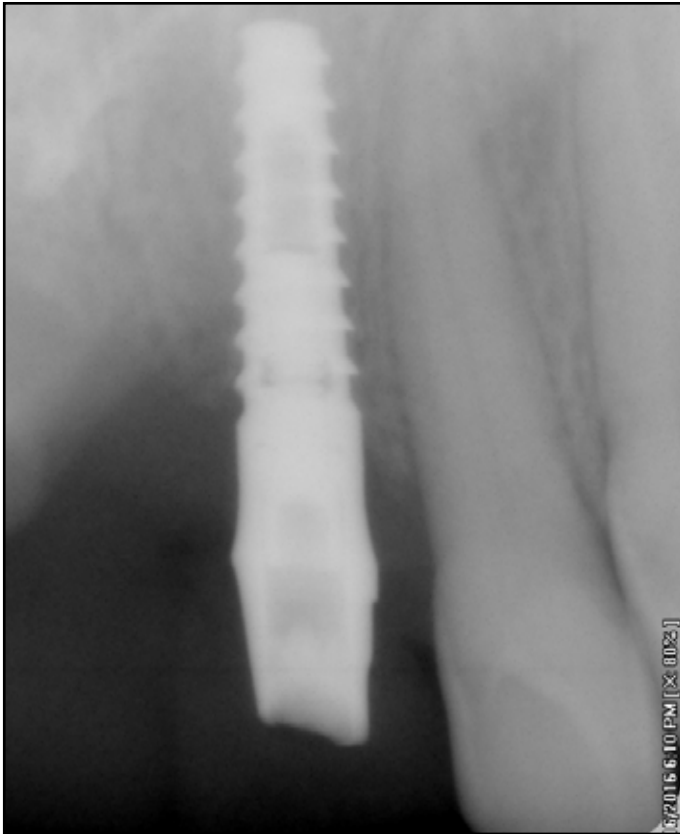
6 months postoperative periapical radiograph showing the implants in place.
